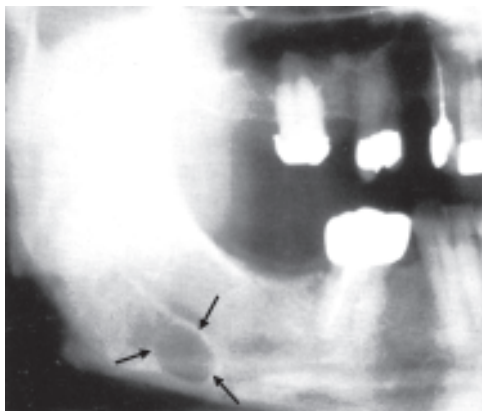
Right side of panoramic radiograph showing the typical cyst-like appearance of Stafne's bone cavity at the angle of the mandible, below the inferior dental canal (arrows)
